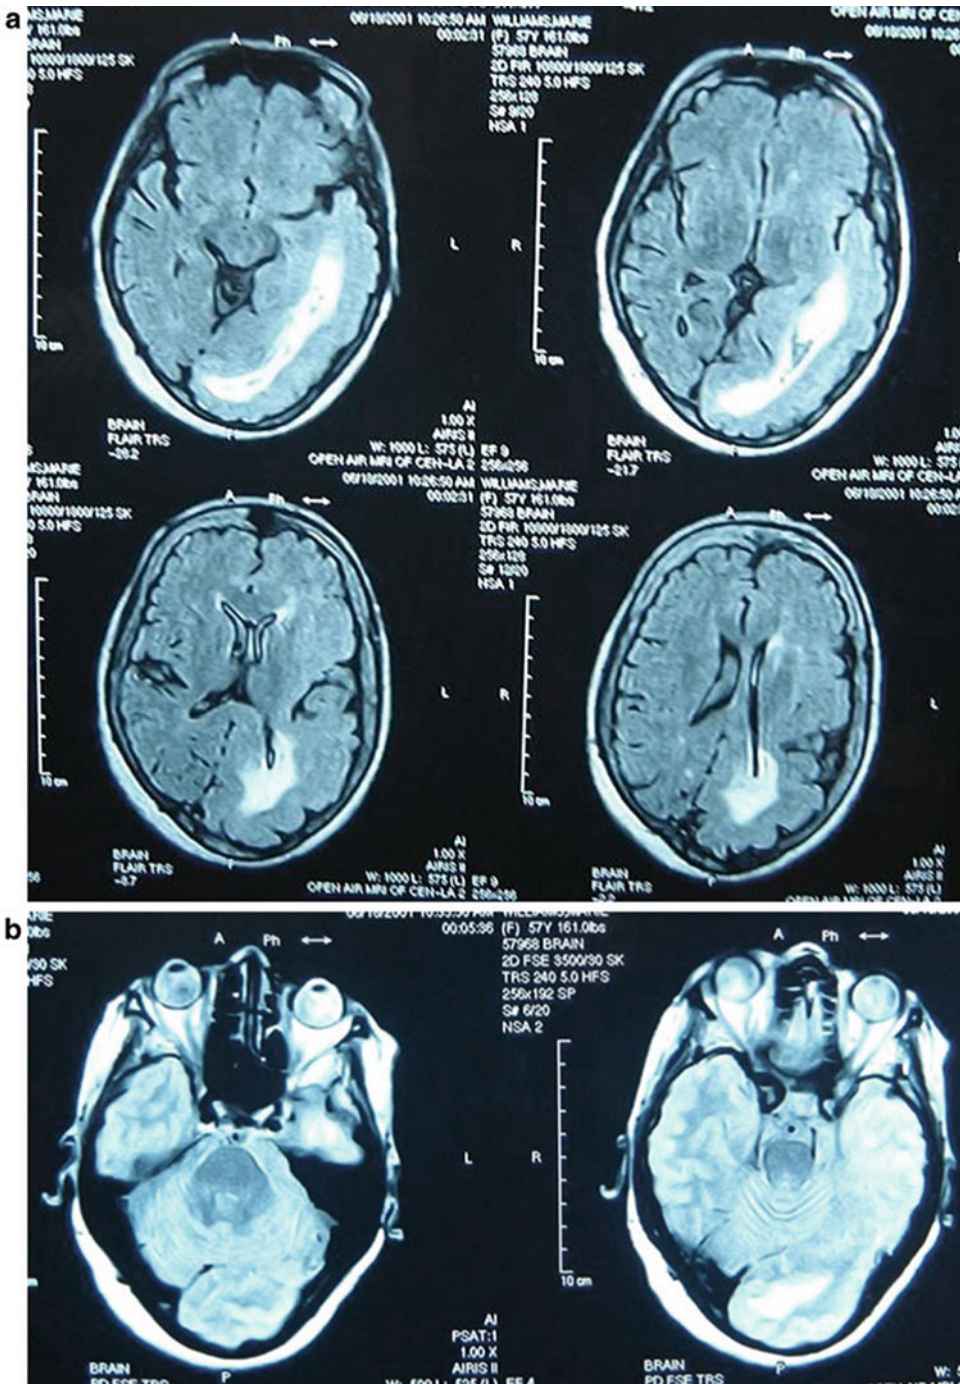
(a, b) The patient's MRI of the brain showed cerebral asymmetry with *left* temporal, occipital, and parietal lobe hypertrophy associated with areas of macrogyria and lissencephaly, consistent with a congenital neuronal migration abnormality
